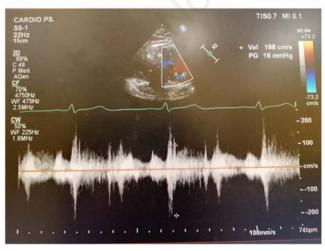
Atrial myxoma in apical four-chamber view on transthoracic echocardiography (upper panel) Color Doppler on mitral valve (lower panel).
